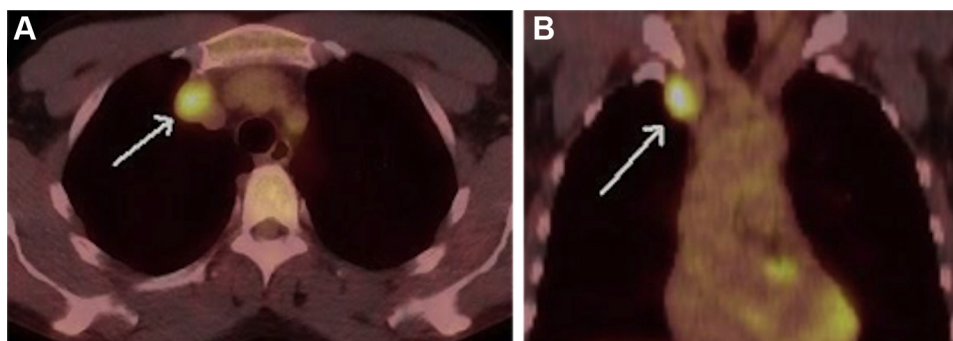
Positron emission tomography (PET) showing a well-circumscribed lesion in the right superior mediastinum with homogeneous moderate fludeoxyglucose (FDG) avidity (*arrows*) on axial (A) and coronal (B) views.
